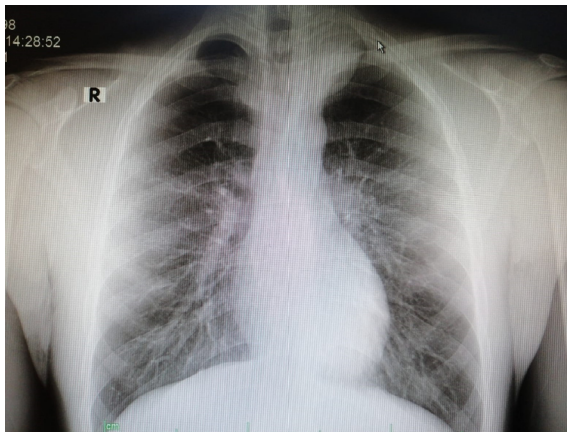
Chest x-ray of the patient. Mass indicated by arrow.
